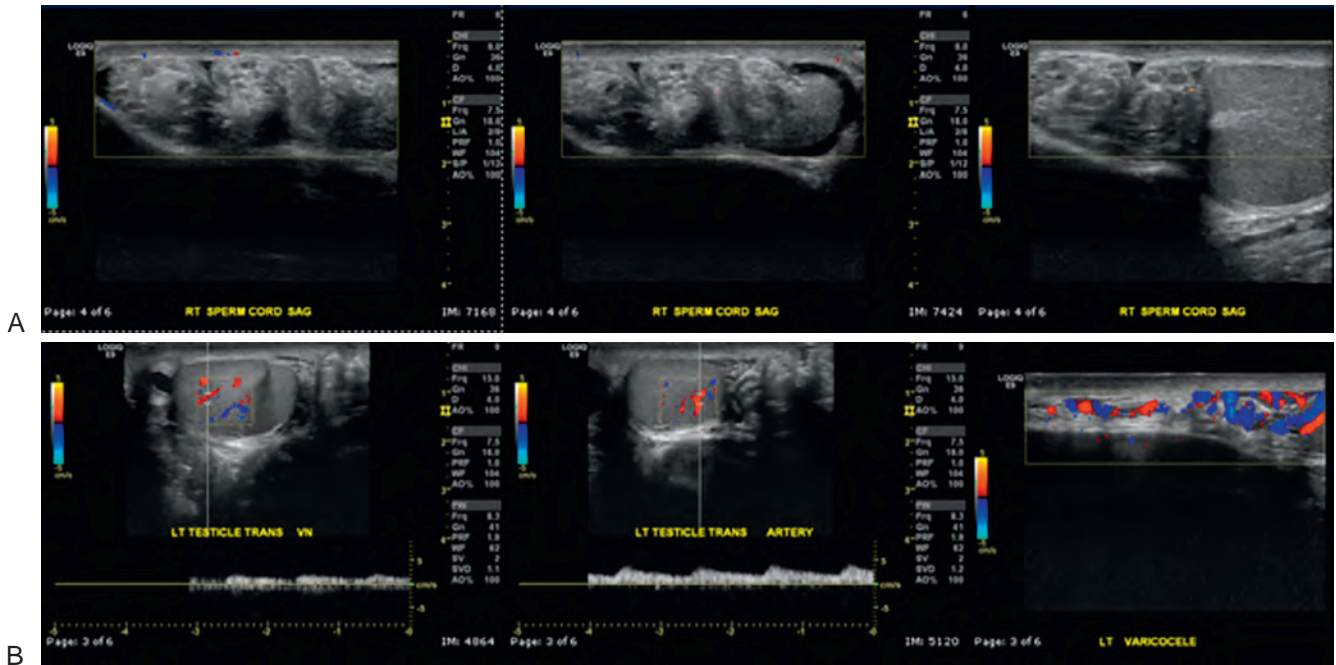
Scrotal sonogram in a 19-year-old man with acute onset of right testis pain. Doppler sonography (A) shows the “whirlpool” sign, which has been associated with torsion of the spermatic cord. Doppler sonography did not identify flow, as compared with the left testis (B), which demonstrated ample flow in the nontorsed cord and testis. An incidental left varicocele was noted as well.
